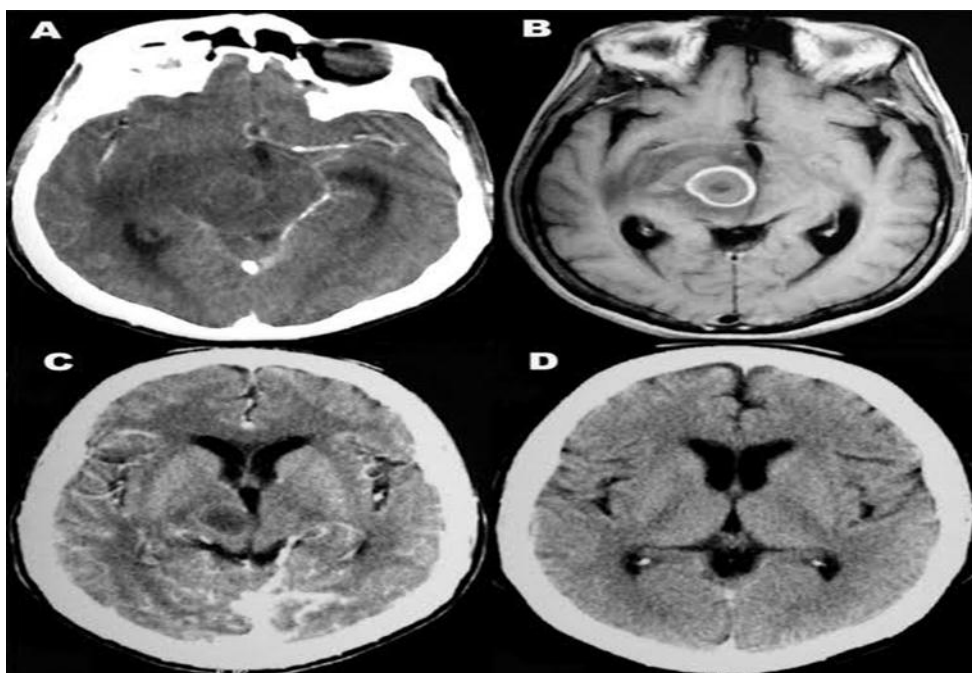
2: Brain CT scans Image
